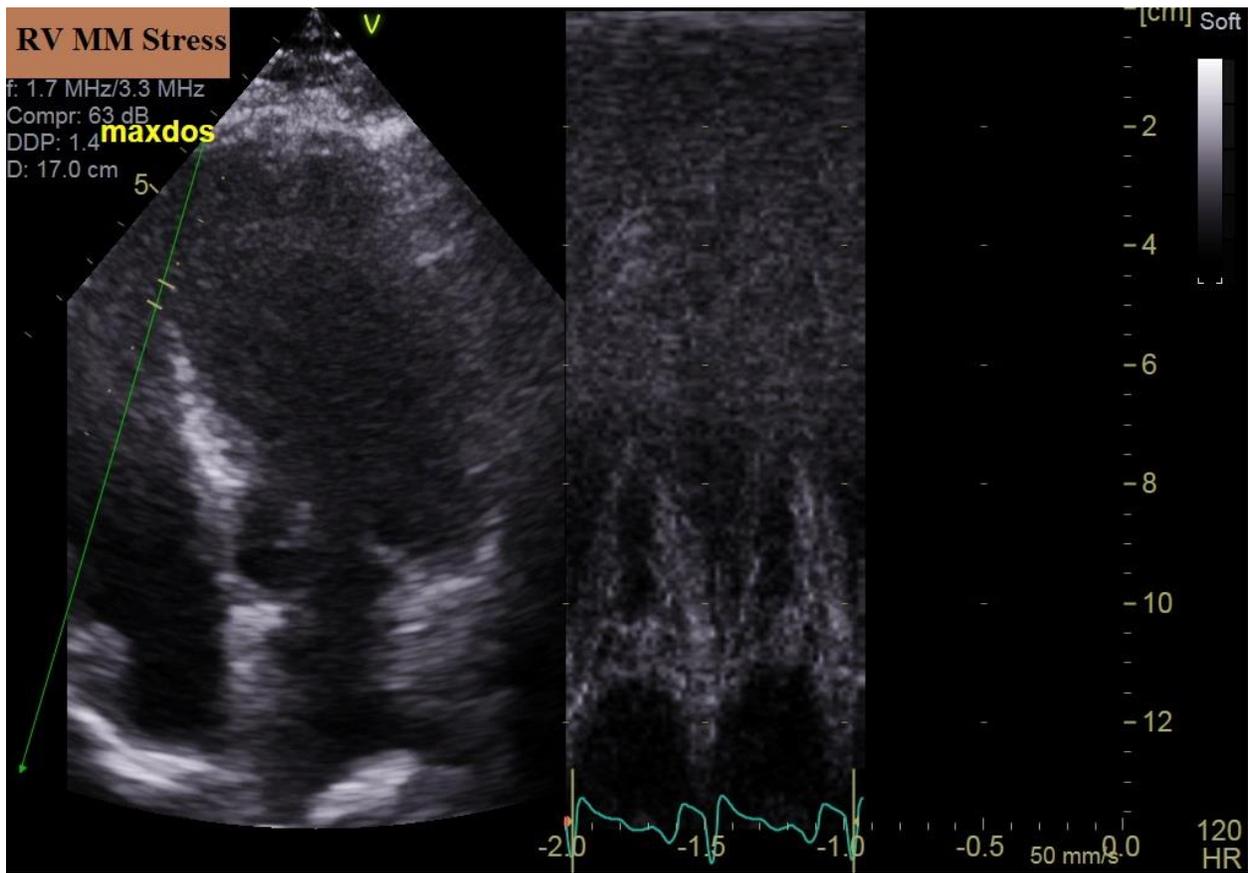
Trans-thoracic echocardiography, Right Ventricle M-mode at peak stress.
